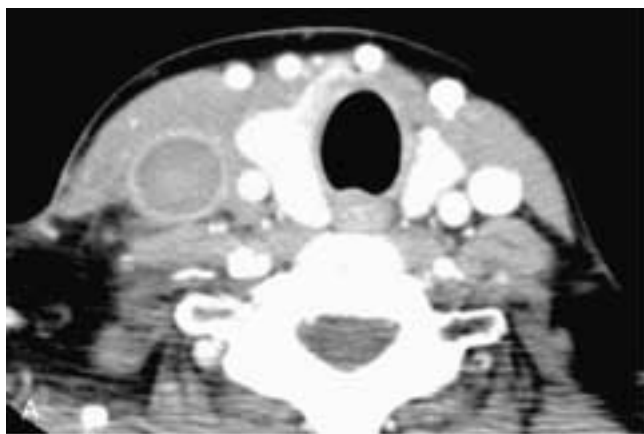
Axial contrast-enhanced CT scan (A) shows a thrombus in the right internal jugular vein. There is slight enhancement of the venous wall due to enhancement of the vasa vasorum. There is also minimal effacement of the surrounding fat planes secondary to a phlebitis. Axial contrast-enhanced CT scan in another patient (B) shows a thrombus in the right internal jugular vein. The thrombus is lucent, and inflammation due to an associated phlebitis obscures the surrounding fat planes.
